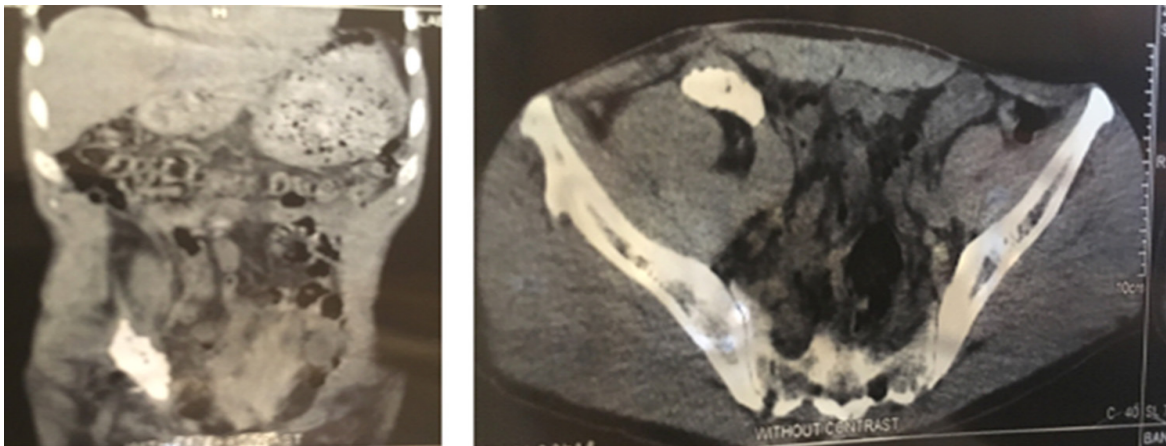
Pre-operative abdomen-pelvic CT scan.
